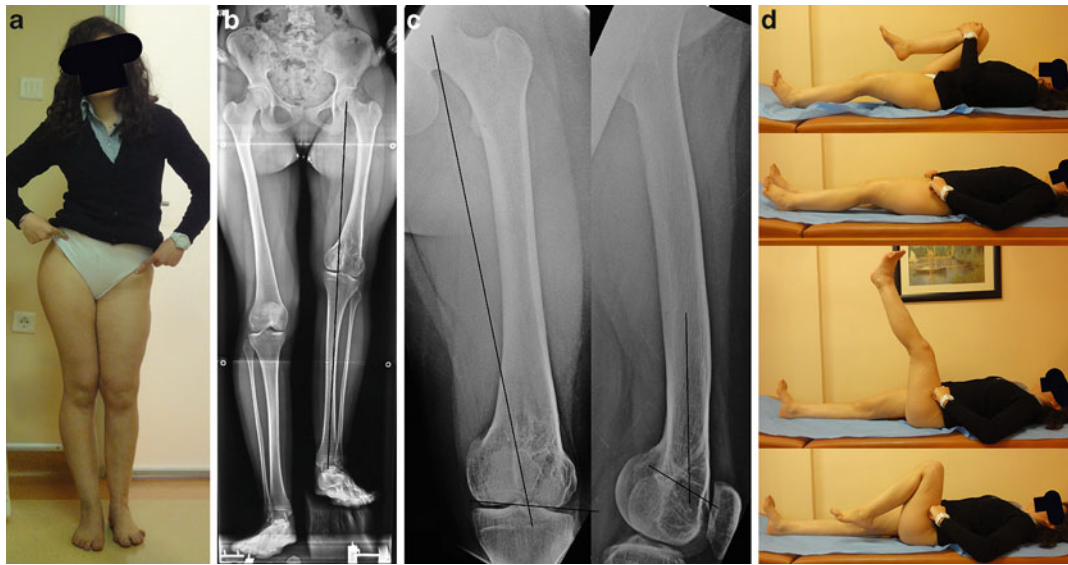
(a, b) Clinical photos and preoperative long-standing radiograph (LSR) with the leg-length difference compensated for using plates. Note the patellae were oriented anteriorly. Note the varus femur and valgus tibia resulting in oblique joint line. (c)
